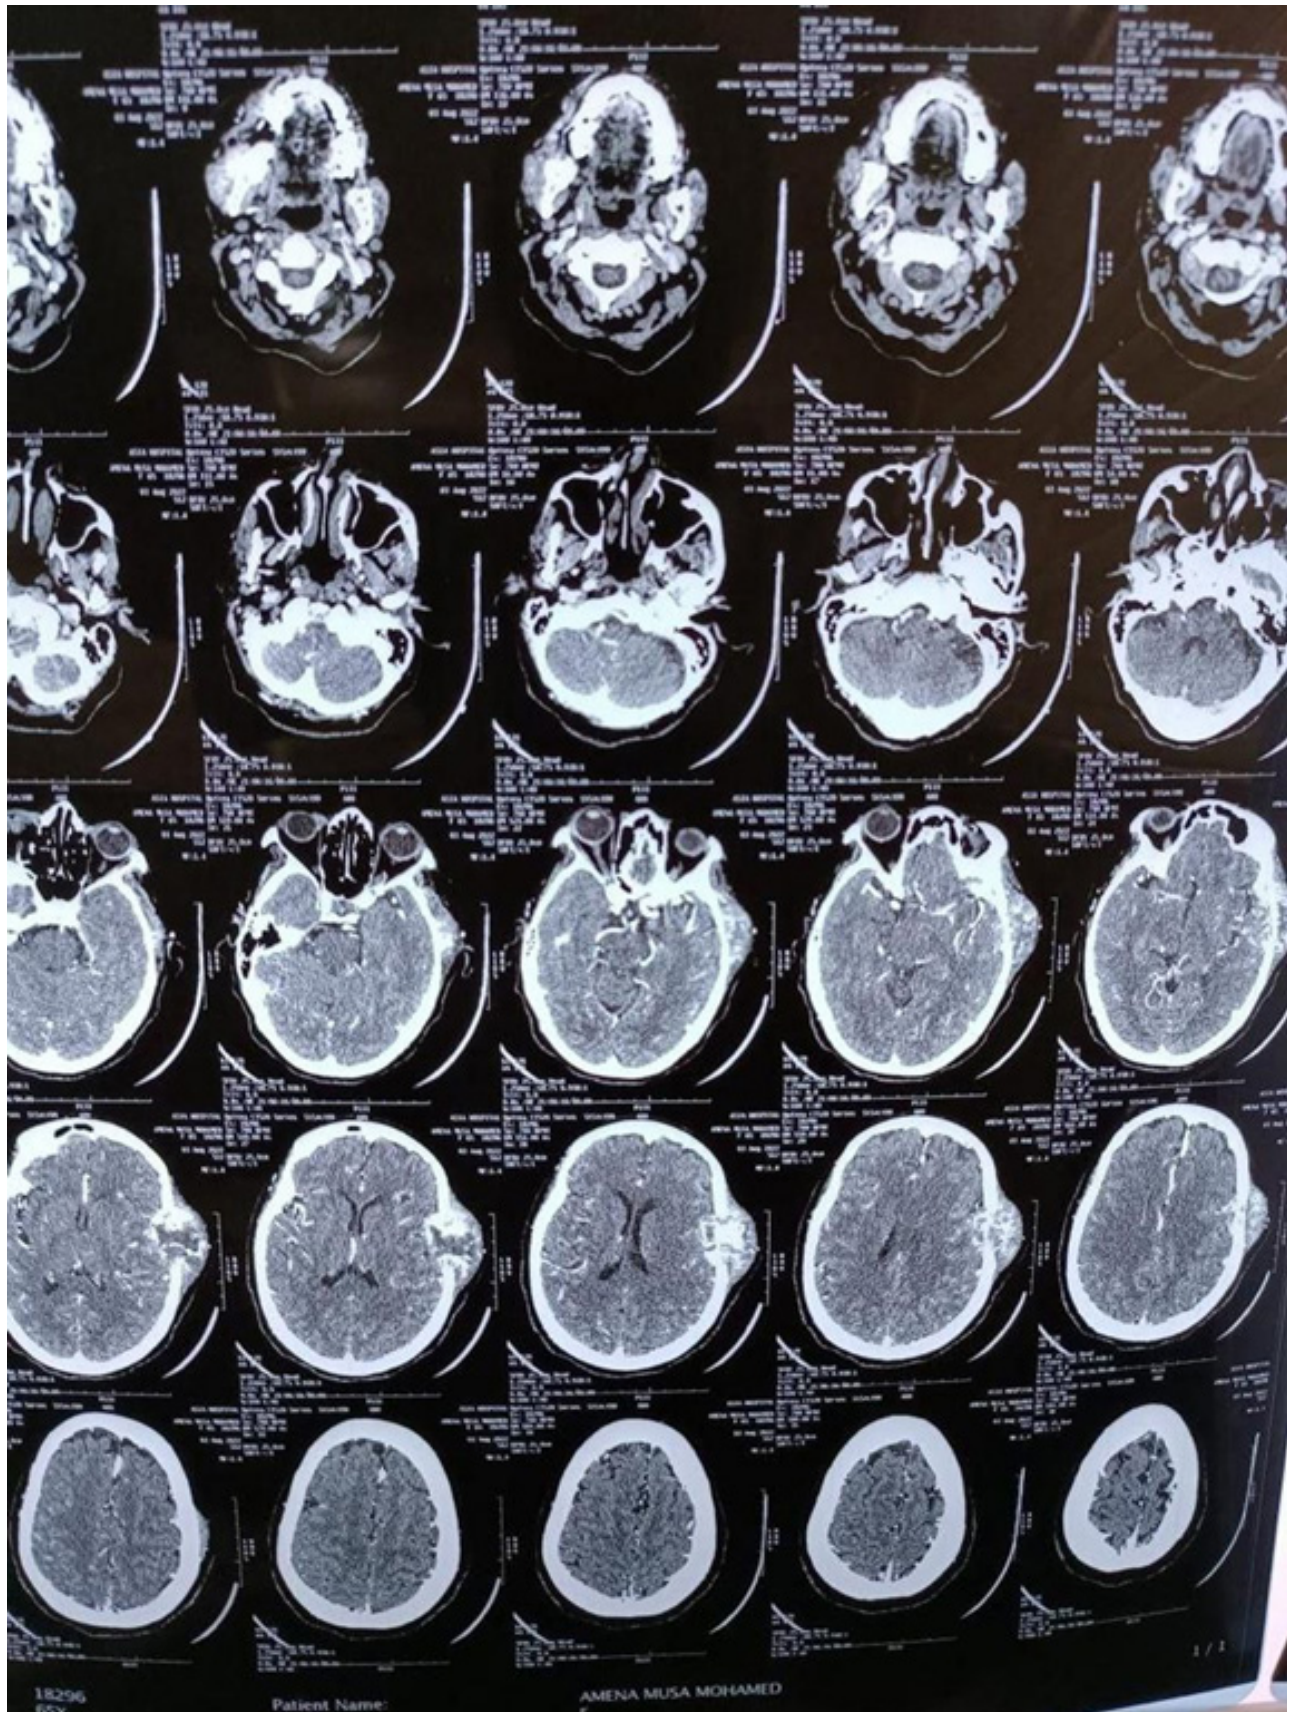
CT scan with contrast, axial cut, soft tissue window shows the lesion with heterogeneous enhancement to the both intracranial and extra cranial parts.
